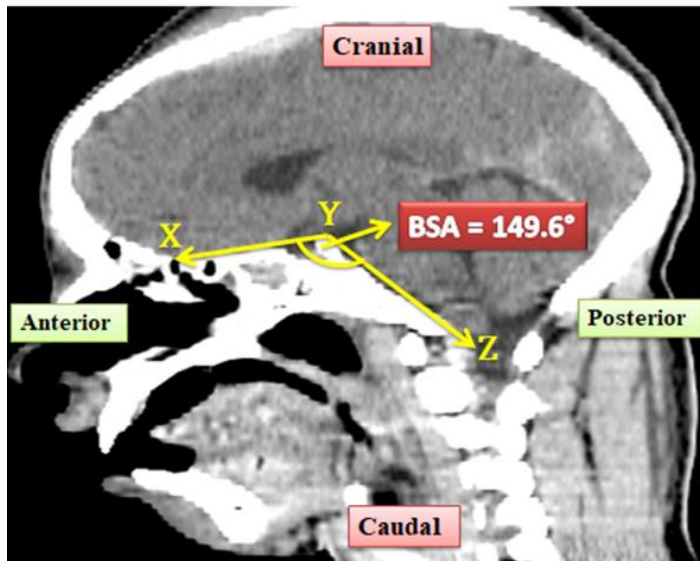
Sagittal Slide of sphenoid sinus CT of a 65-year-old male showing partial flattening of the skull base and landmarks of measurements of the basal sphenoid angle.
